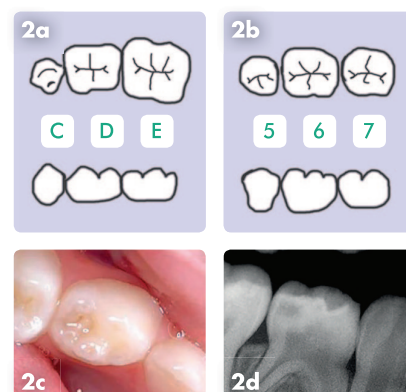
Proximal surface caries develop just below where the adjacent teeth touch. (a) Broad contact areas of primary molars and (b) contact points of permanent molars: the larger contact areas on primary molars make it more difficult to detect the early stages of proximal caries development prior to gross enamel breakdown, by direct visualisation; (c) Indistinct grey shadowing of the mandibular right first primary molar (visible even when wet but would be clearer when dry) is indicative of caries extending into dentine; (d) Radiograph of the same tooth showing the extent of the lesion
